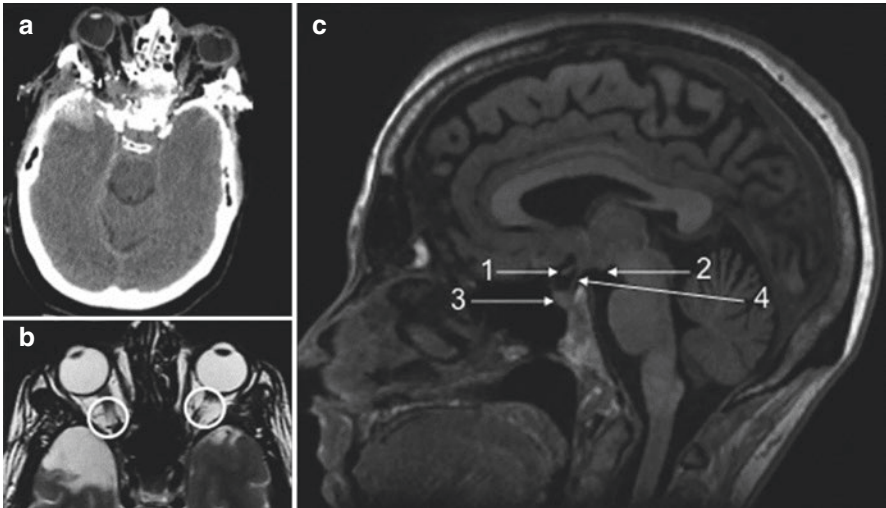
(a) Computerized tomography of the head showing damage of the optic nerves bilaterally following a gunshot wound to the right temple. Note bone fragments along the bullet path across the suprachiasmatic area. (b) Axial T2-weighted magnetic resonance imaging (MRI) of the head showing bilateral optic nerve hyperintensities consistent with nerve damage (circles). (c) Sagittal T1-weighted MRI of the head. The optic chiasm (arrow 1) forms the anterior boundary of the hypothalamus. The infundibulum (arrow 4) to the pituitary gland (arrow 3) and the mammillary bodies (arrow 2) form the inferior boundary of the hypothalamus. The optic chiasm appears thinned along with the adjacent hypothalamus. (From DelRosso et al. [9])
